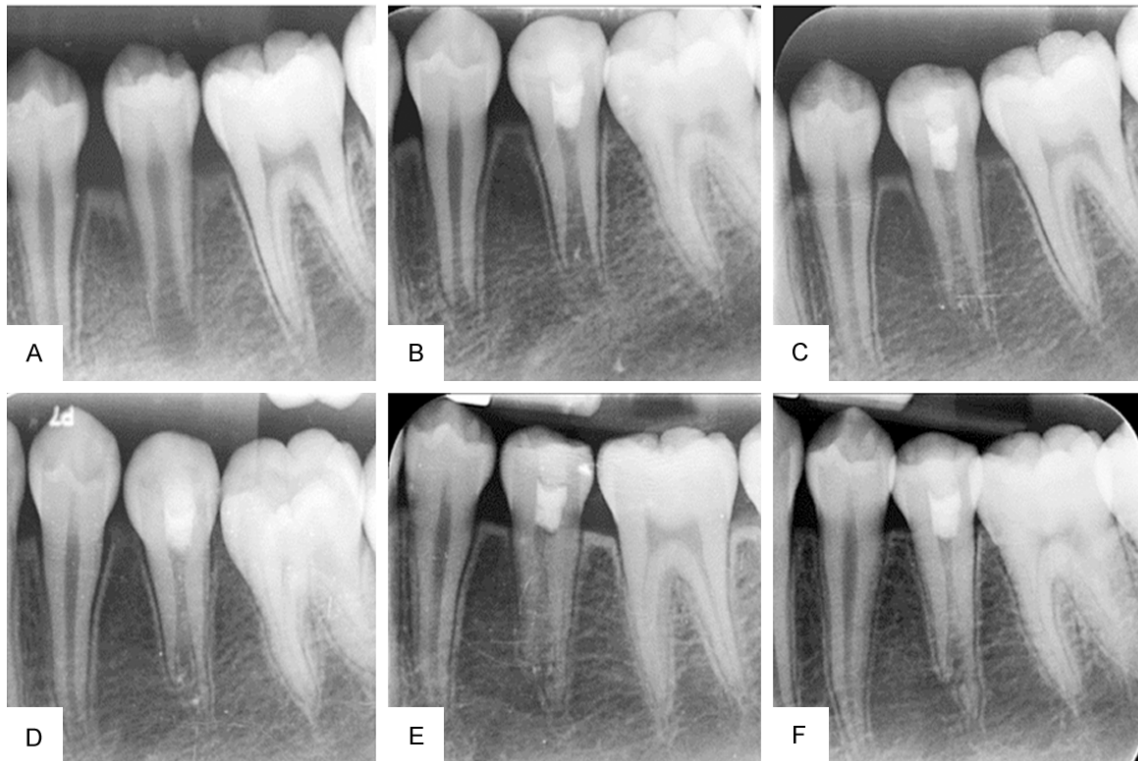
Periapical radiographs in case 3. A. Preoperative intraoral periapical radiograph showing an incomplete apex with a periradicular radiolucency of tooth #20. B. The 3-month follow-up radiograph showing that the periradicular radiolucency healed completely. C. The 6-month follow-up radiograph showing the elongation of the root. D, E. Radiographs taken after 9 and 12 months showing continued root development. F. The 18-month follow-up radiograph showing complete root development and a lateral opening in the mesial wall of the root.
